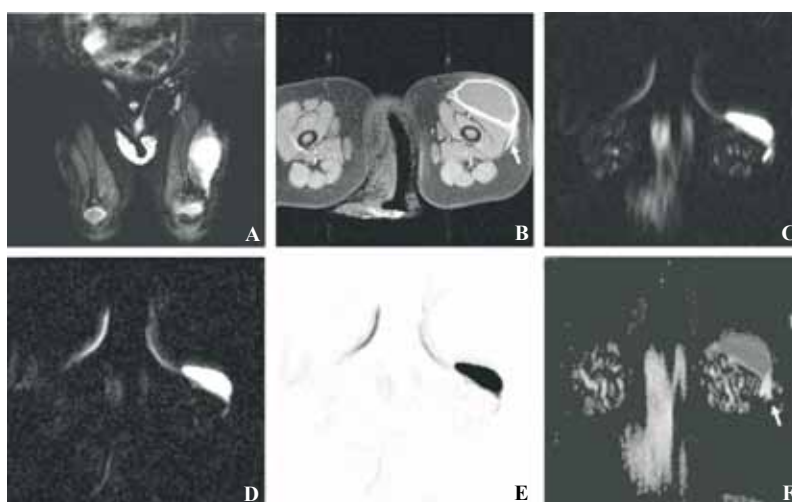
Patient 6, sterile chronic post-vaccinational soft tissue abscess on the left upper leg of a 12-month old boy [coronal T2 TIRM (A), transversal post-contrast T1 TSE FS (B), DWI $b=0$ (C), DWI $b=1000$ (D), DWI $b=1000$ inverted gray-scale (E), ADC map (F)]. The abscess shows bright fluid signal on T2 TIRM (A) and strong peripheral contrast enhancement on T1w (B). High signal intensity on DWI with high b -value, equaling restricted diffusion, is seen within the abscess (D, E). Mean ADC was $0.78 \times 10^{-3} \text{ mm}^2/\text{s}$. There is perifocal inflammatory contrast enhancement adjacent to the lateral abscess contour (arrow, B), which appears in bright gray on the ADC map (arrow, F) with a mean ADC of $1.6 \times 10^{-3} \text{ mm}^2/\text{s}$, suggestive of oedematous soft tissue.
